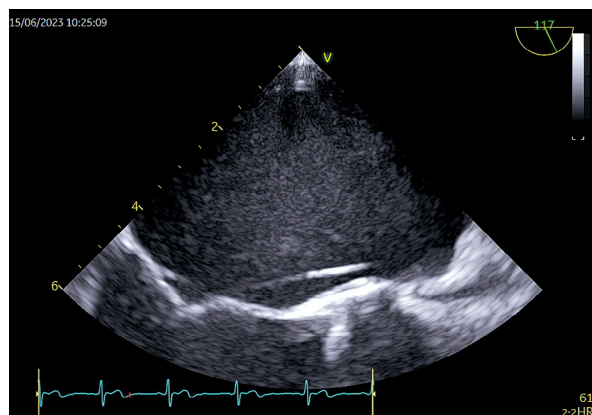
LAMB in transesophageal echocardiographic examination (TEE)
